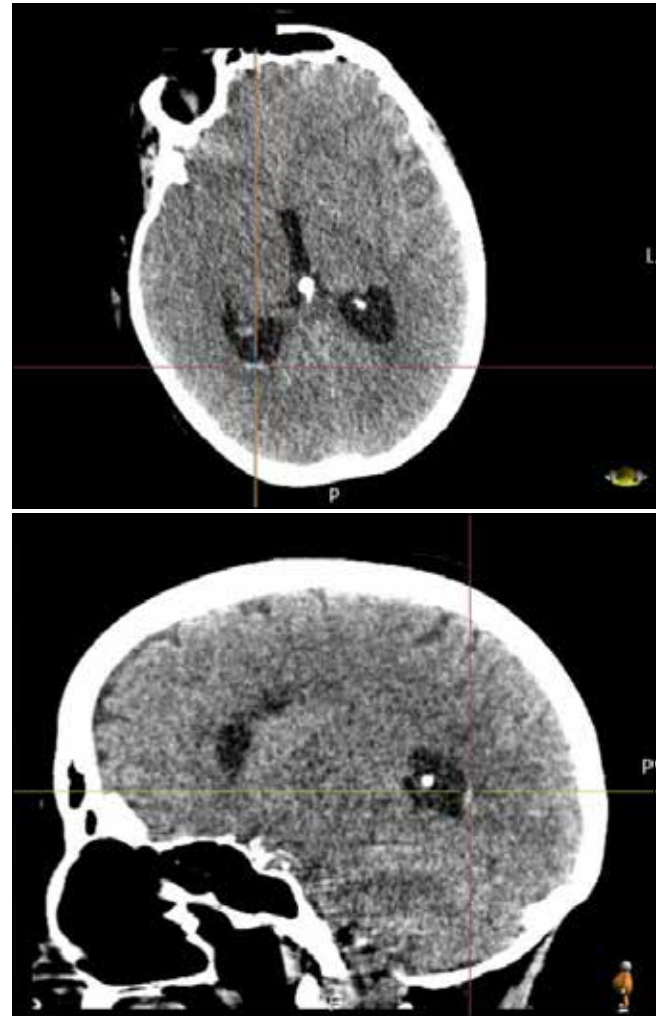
CT brain cross sectional images showing, high density material in the dependent part of right lateral ventricle (at centre of crosshairs).
